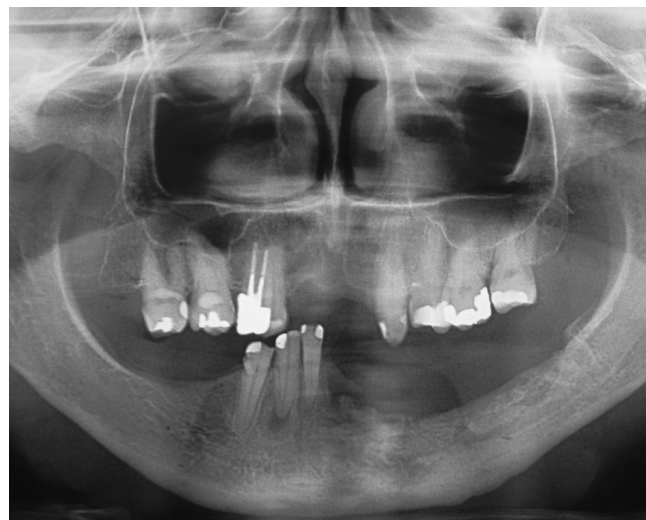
Initial radiographic image, with bone exposure and bone density alterations in the right anterior mandibular region
